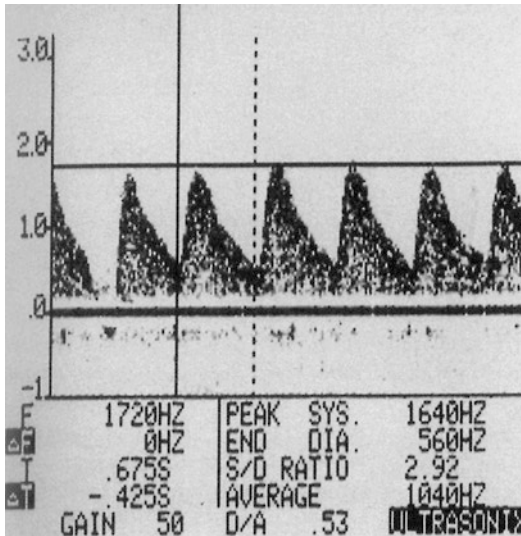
Continuous-wave Doppler sonogram derived from the umbilical arteries. It was obtained with a free-standing Doppler device without duplex imaging guidance. *Vertical axis* represents the magnitude of the Doppler shift in kilohertz and the *horizontal axis* the time. *Bottom*: Peak systolic (*S*), end-diastolic (*D*), and average frequency shift (*A*) values. The indices (*S/D*, *D/A*) are also shown
